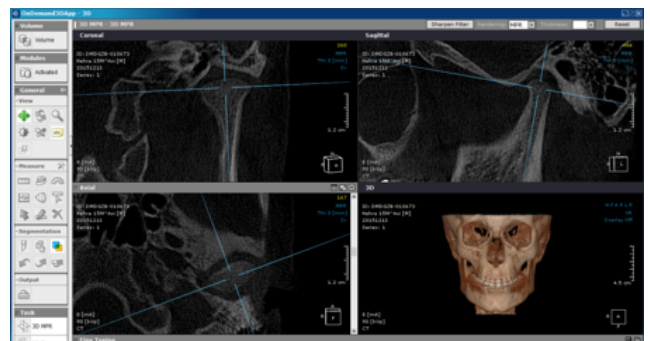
CBCT imaging device
